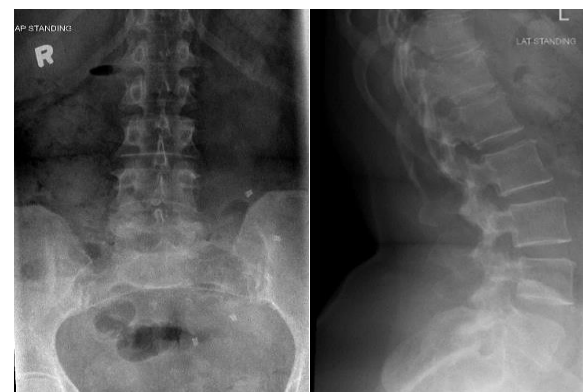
Anteroposterior (AP) (left) and lateral (right) radiographs of the lumbosacral spine showing mild degenerative changes at the lumbar spine with no significant listhesis of the vertebra bodies
